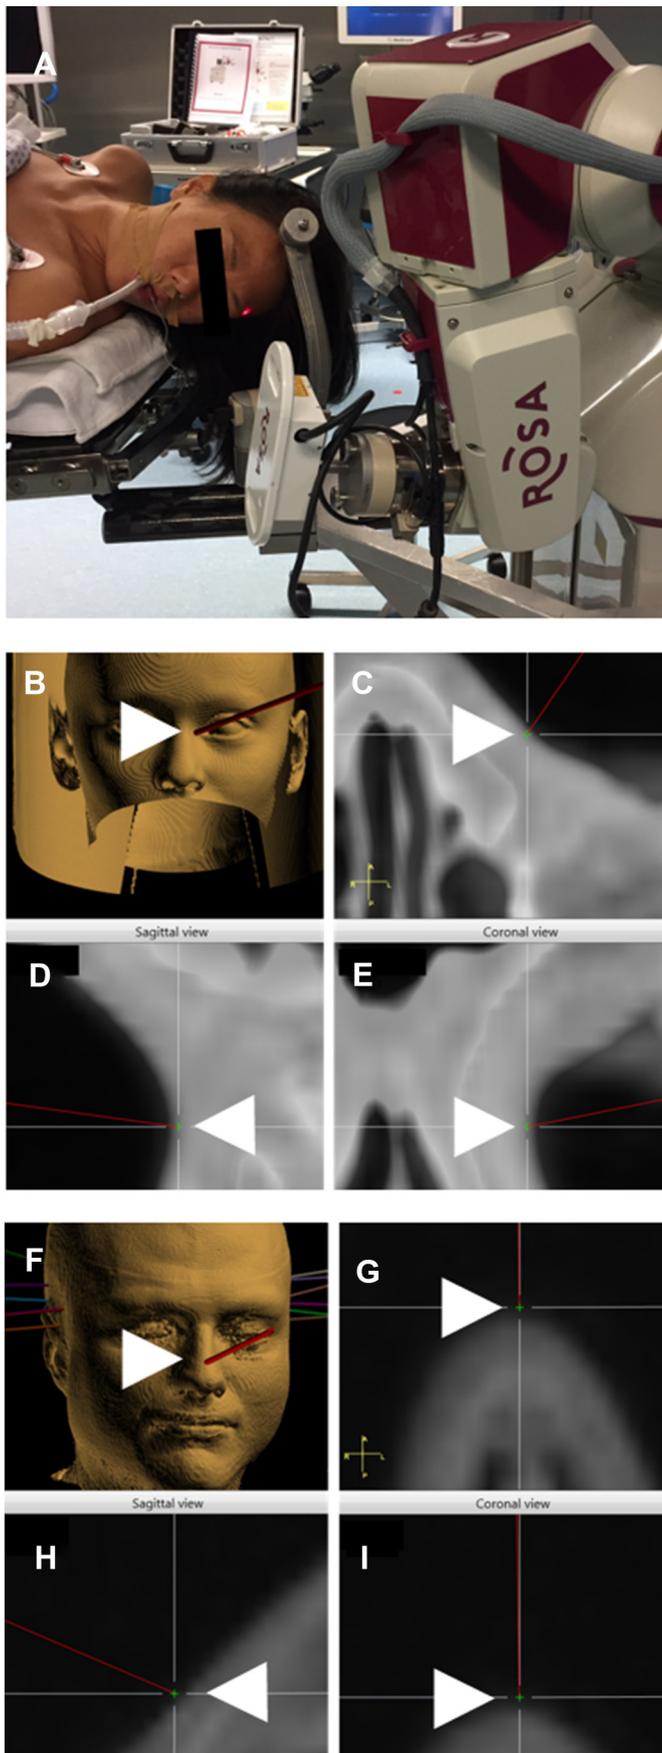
Referencing with CT and MRI datasets and laser scan of the patients' surface (CT-laser, 3.0-T MRI-laser referencing). A) Surface matching. The laser scanner is fixed to the robot; the laser beam is seen as a small red spot on the patients face. B) Position of the laser beam during surface registration on 3D reconstruction of the thin-layer CT scan (CT-laser referencing), C) laser beam on axial-, D) sagittal-, and E) coronal-CT slices, respectively. F) Position of the laser beam during surface registration on 3D reconstruction of MRI (3.0-T MRI-laser referencing), G) laser beam on axial-, H) sagittal-, and I) coronal-MRI slices, respectively. It is visible, that the MRI 3D reconstructions and slices are not as even as the CT scans.
